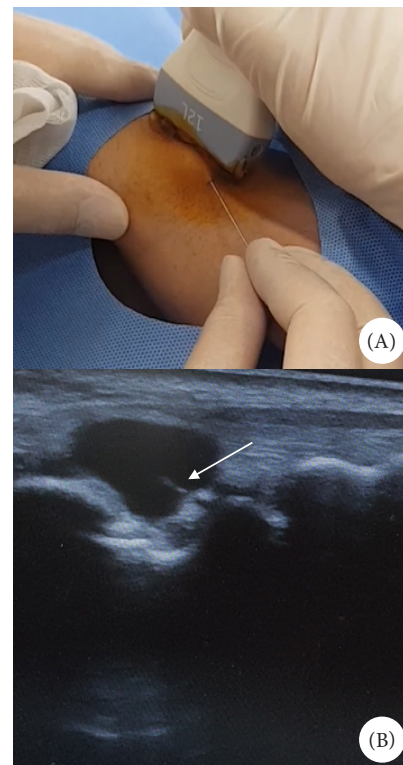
(A) Acupotomy treatment (under the ultrasonographic guidance) of the dorsal ganglion cyst. (B) Acupotomy needle peeling around the swollen point of the ganglion cyst (ultrasonographic observation).
